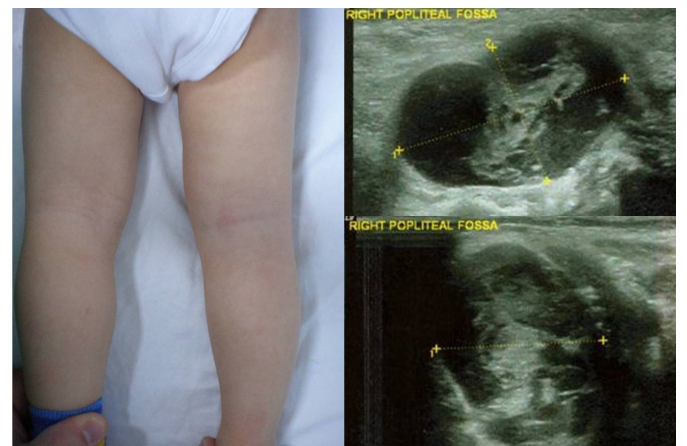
A 21-month-old boy presented with a two-day history of a nontraumatic popliteal cyst. Doppler ultrasound revealed heterogeneous internal echogenic tissue without vascularization.
